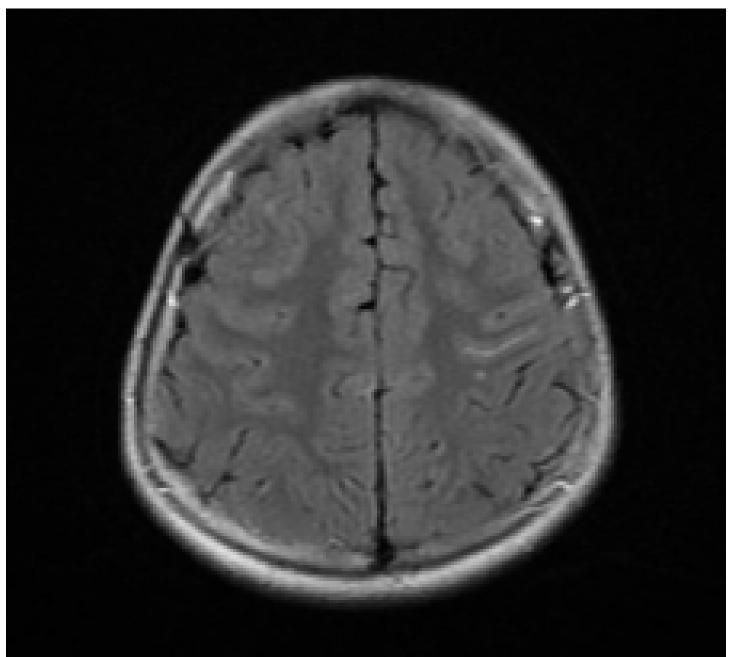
Brain MRI, axial FLAIR, from initial hospital admission, day 1, showing mild signal abnormality in some cerebral sulci, clinically consistent with meningitis.
